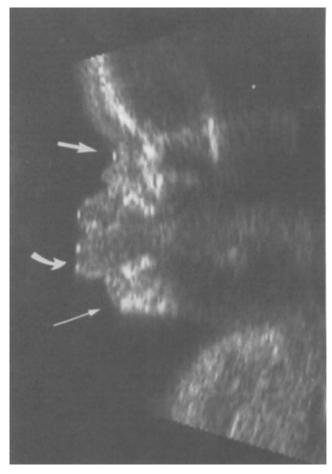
Patient 2, ultrasound imaging of the fetal profile at 21 weeks of gestation demonstrates virtual absence of nasal bridge and nasal hypoplasia suggestive of the "saddle-nose" defomity. Mandible, lips, and depressed nasal bridge are indicated by the narrow, curved, and large arrows, respectively.
